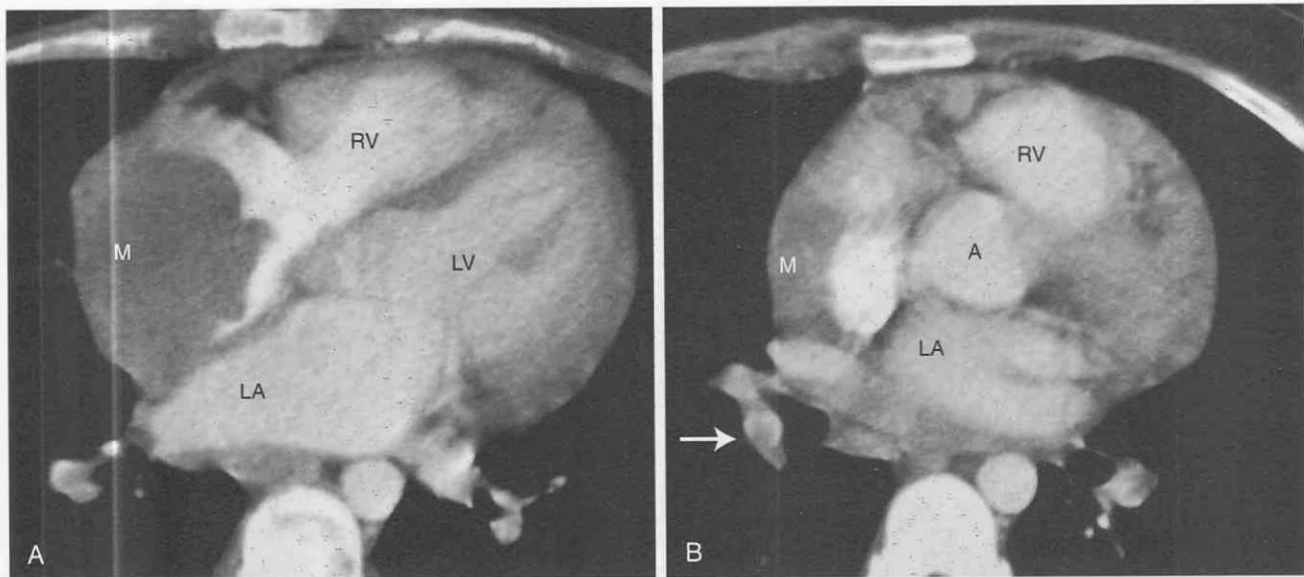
Angiosarcoma in a 23-year-old man. Contrast-enhanced axial CT images. A, A large mass occupying most of the right atrium. LA, left atrium; LV, left ventricle; M, mass; RV, right ventricle. B, Image more cephalad shows a filling defect in the right lower lobe pulmonary artery, consistent with tumor thrombus (arrow). The patient had pulmonary and bony metastases as well (not shown). A, ascending aorta; M, mass.
